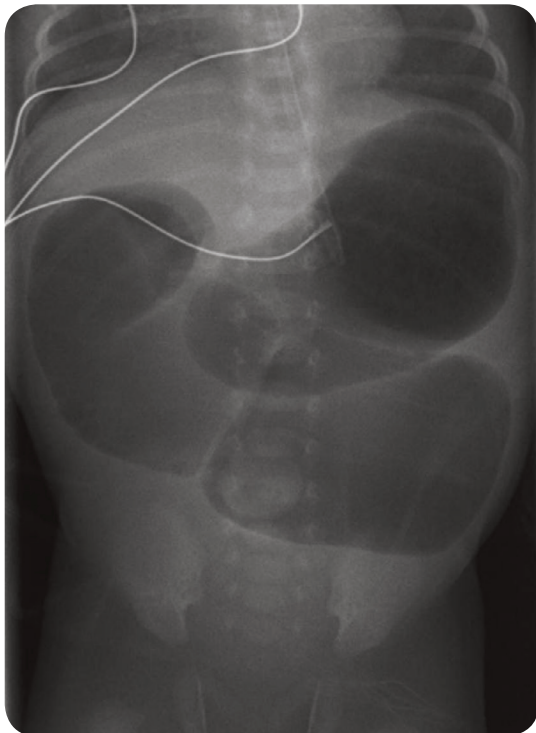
A plain abdominal radiograph of a neonate demonstrating the triple bubble sign of jejunal atresia.
